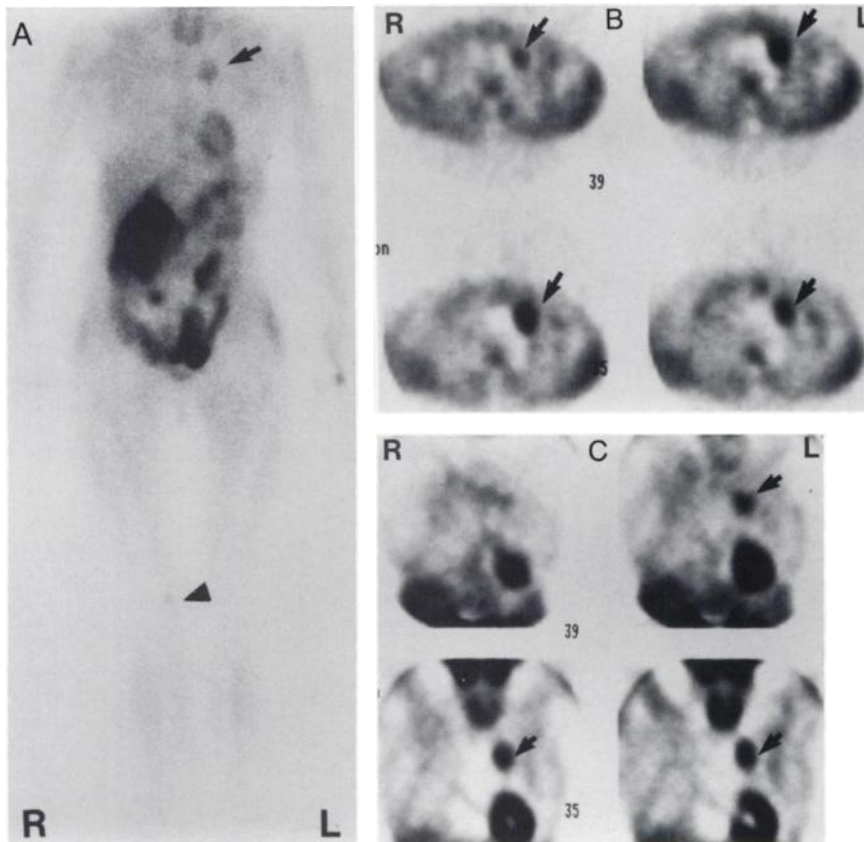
Sestamibi tumor scan after administration of 30 mCi of MIBI. Anterior whole-body planar view (A) demonstrates increased MIBI uptake in the thoracic tumor (arrow) and faint increased uptake in distal right femoral metaphysis (arrowhead) compatible with solitary bony metastasis. Transverse (B) and coronal (C) SPECT images of the thorax demonstrate intense increased activity in the tumor (arrow) adjacent to the aortic arch (photogenic area). Normal MIBI uptake is seen in thyroid, heart and bone marrow of the spine.
